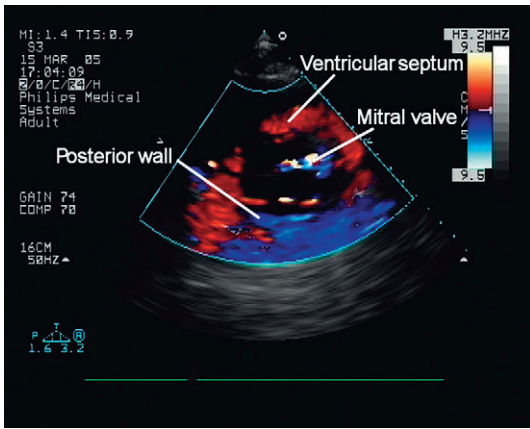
A longitudinal Doppler tissue image of a section through the left ventricle of the heart.
